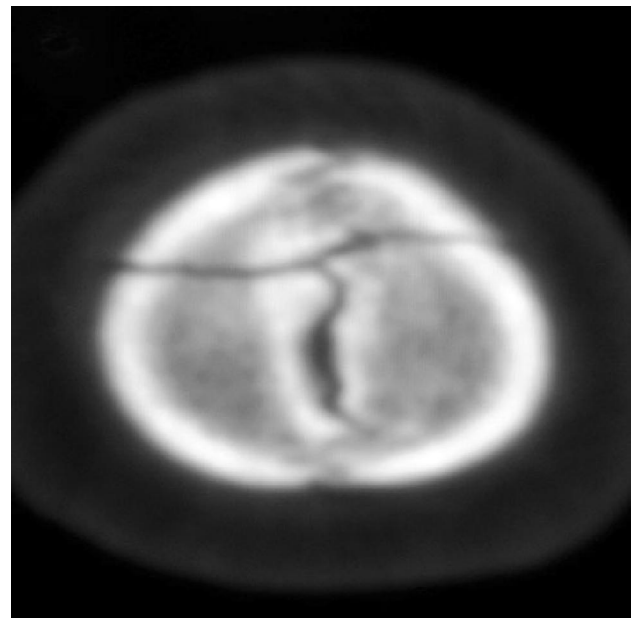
Bone window of a CT scan image showing linear oblique fracture involving bilateral parietal bones at vertex and sagittal suture. It is important to include the vertex to diagnose such hidden fractures.
